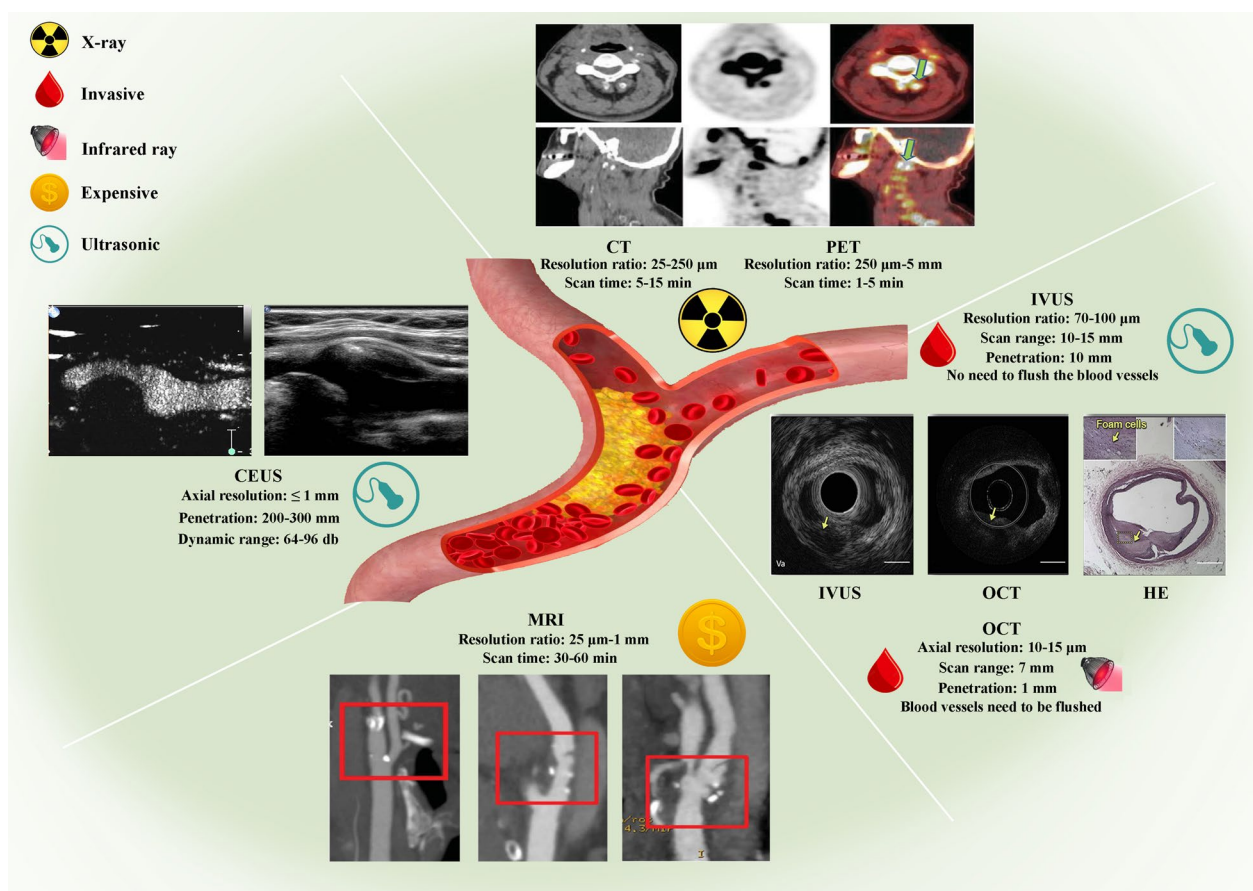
Conventional imaging diagnosis of atherosclerosis. Noninvasive imaging techniques for atherosclerotic plaques include CT, PET, MRI and CEUS, while the main invasive imaging techniques are OCT and IVUS. This figure shows the sensitivity, relative costs, resolution range and scan time range. MRI, CT and PET images were obtained from ref. [10]; CEUS images from ref. [127]; and IVUS and OCT images from ref. [128]. All of the imaging devices mentioned above have been approved by the FDA
